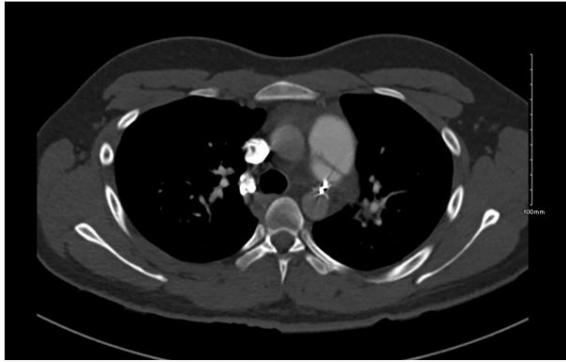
CT scan demonstrating PAD and Amplatzer ductal occluding device.
